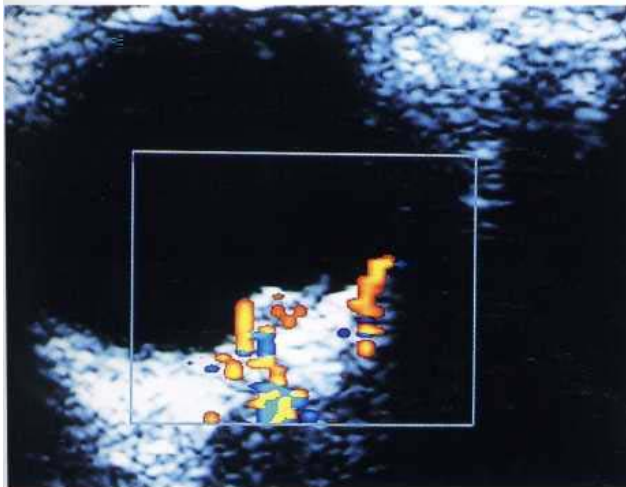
Colour Doppler scan showing choroidal haemangioma.
